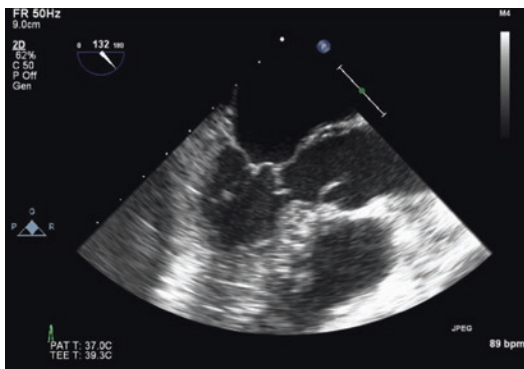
Transesophageal image of a subaortic membrane located in the left ventricular outflow tract and also attached to the base of the anterior mitral valve leaflet
